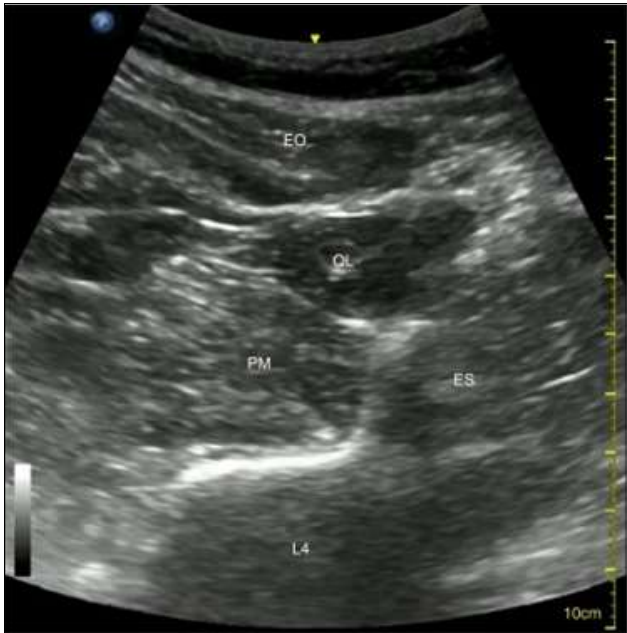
Ultrasound picture of the QL type II before a local anaesthetic was injected (EO = external oblique, ES = Erector Spinae, L4 = Lumbar 4, PM = Psoas Major, QL = Quadratus Lumborum)
